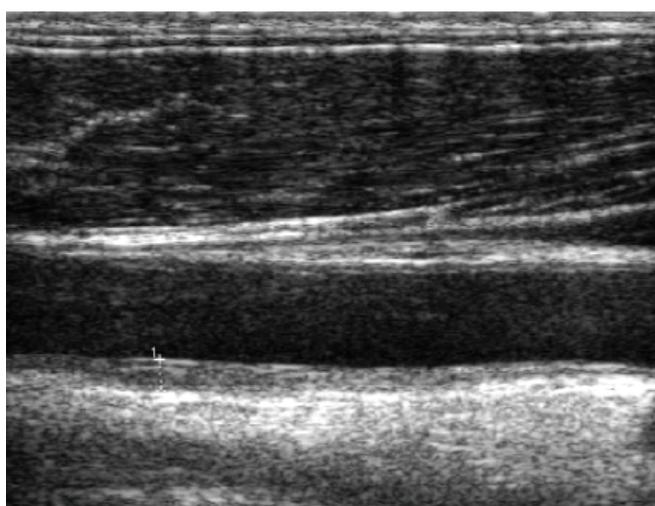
Ultrasound scan of carotid artery showing increased CIMT without plaque
